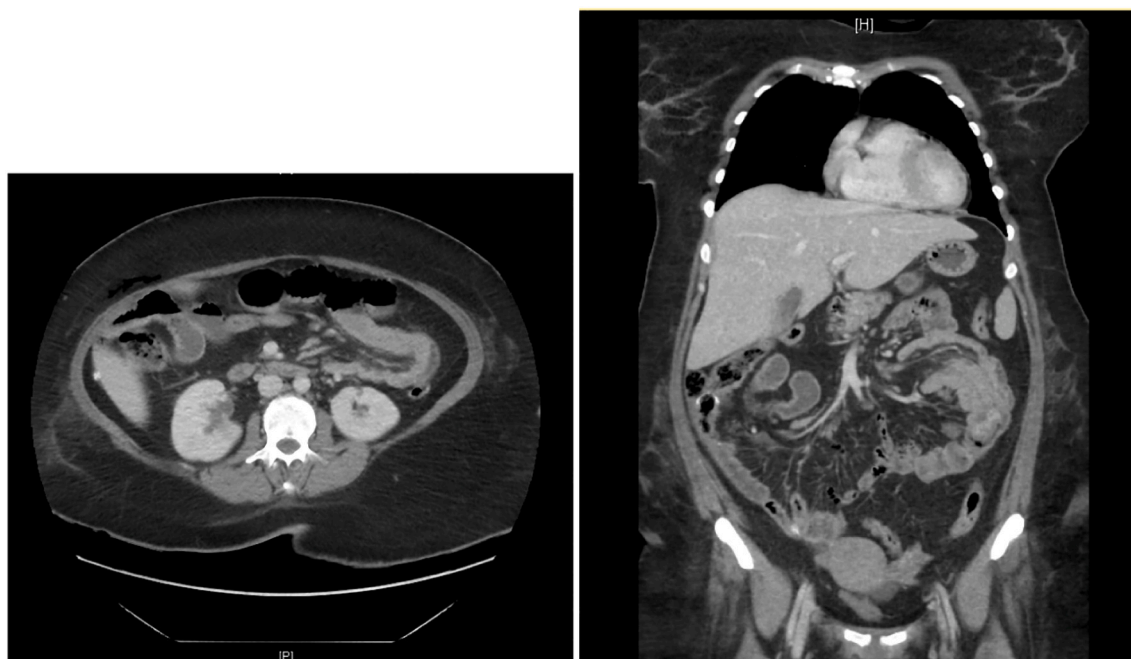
CT abdomen showing intussusception of jejunal loops with signs of hemorrhage and partial obstruction with Lung and liver mets.
